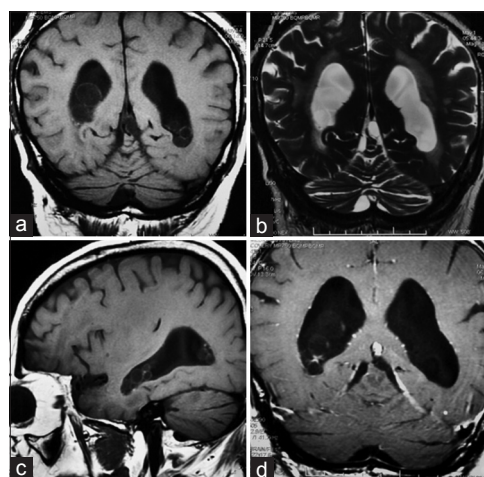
Brain magnetic resonance imaging showed multiple small cysts with cerebrospinal fluid-like signal inside within the lateral ventricles (a and c) T1-weighted, (b) T2-weighted and no enhancement (d) T2-weighted with contrast-enhanced)
